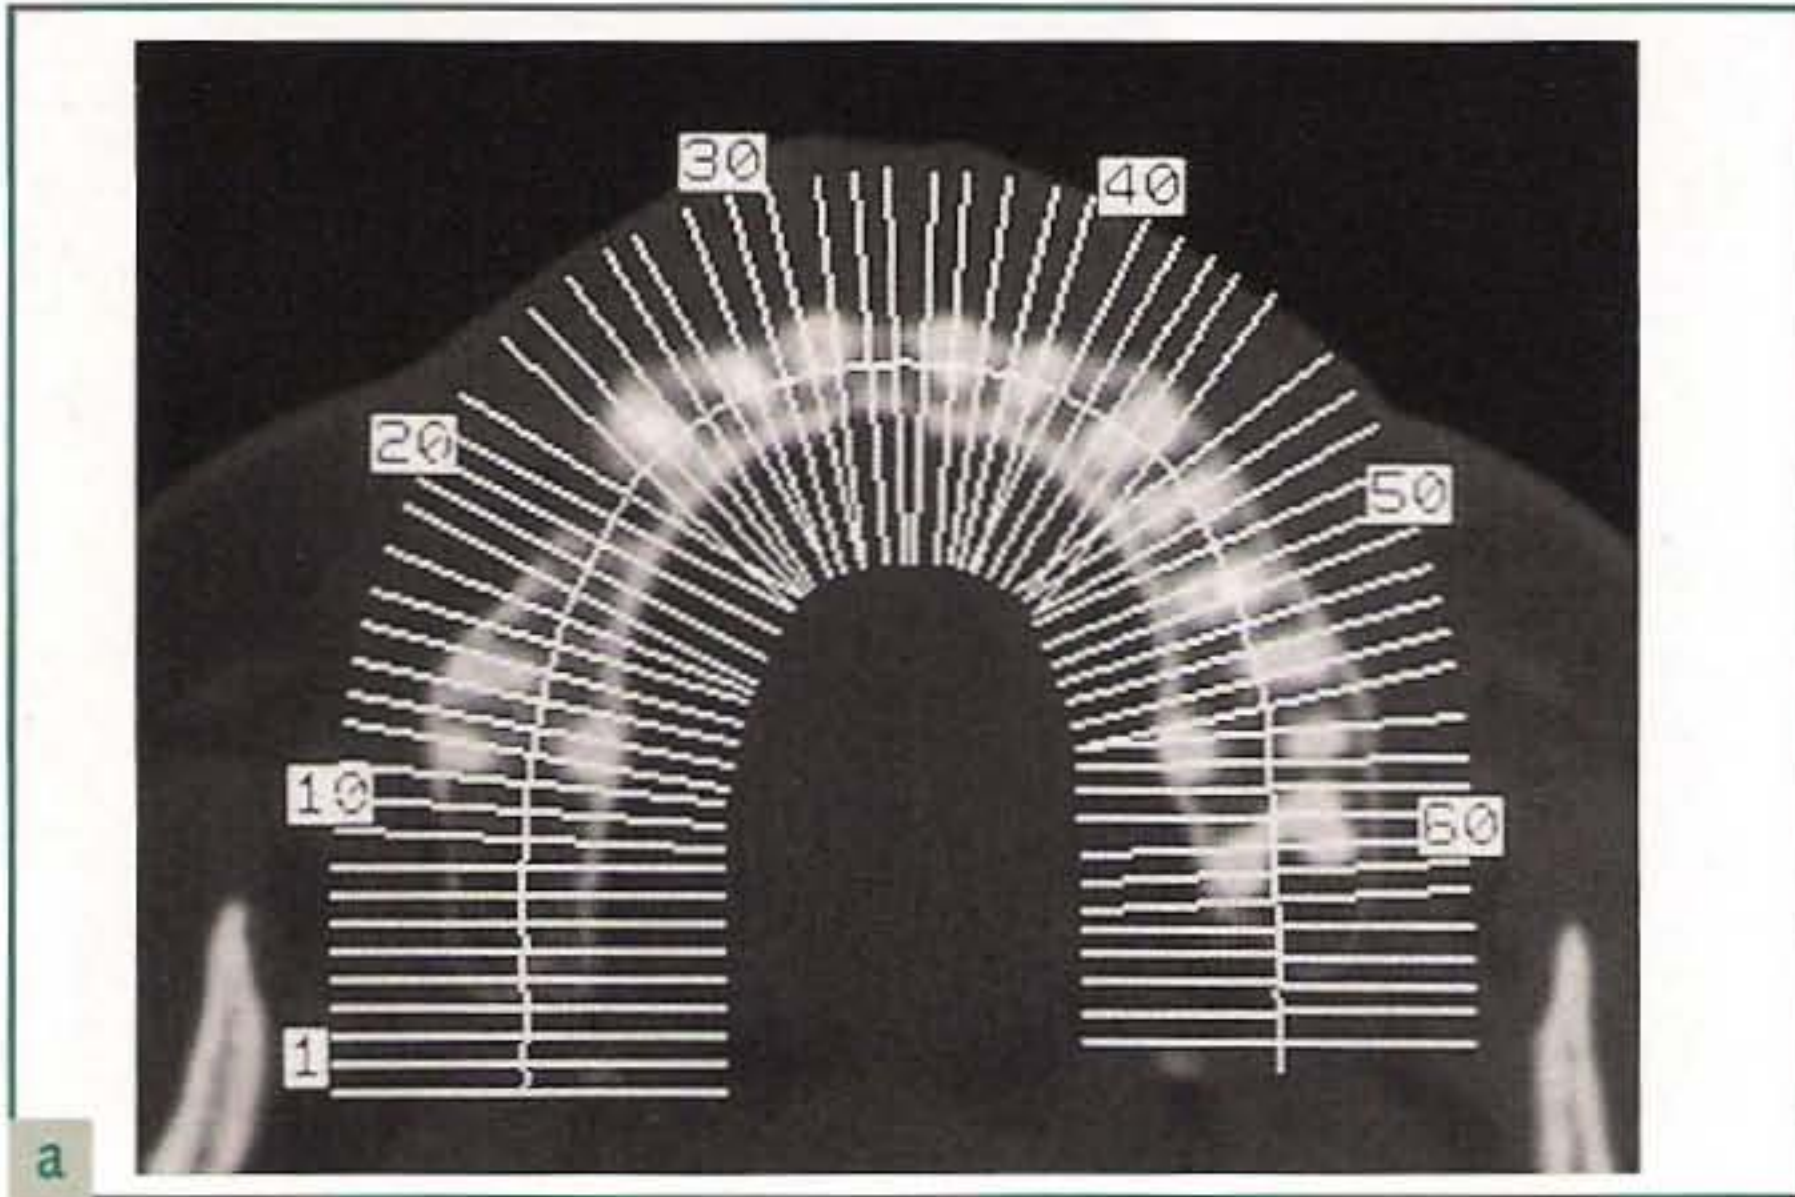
(a and b) The CT scan allows the deficiency of the residual bone around the maxillary right first premolar to be diagnosed. (Figs 9-114 to 9-127 courtesy of Dr Carlo Tinti.)
